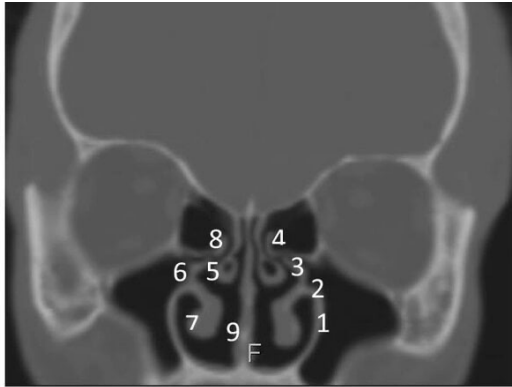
Coronal CT image demonstrating the osteomeatal complex and nasal cavity anatomy: (1) Maxillary sinus, (2) Maxillary ostium, (3) Infundibulum, (4) Ethmoidal bulla, (5) Middle nasal turbinate, (6) Uncinate process, (7) Inferior nasal turbinate, (8) Hiatus semilunaris, (9) Nasal septum. [30]
